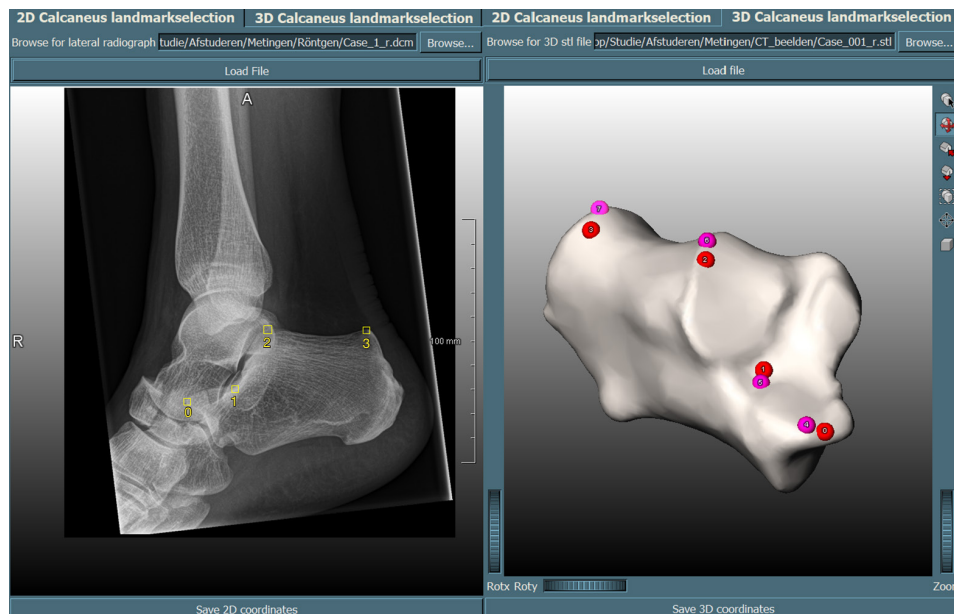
Screenshot of the developed Graphical User Interface to measure Böhler angle and the Critical angle of Gissane. (Left) two-dimensional radiographs measurements on the calcaneus; (right) 3D measurements on 3D models of the calcaneus. The selected landmarks by the observers are depicted with red, and the corrected landmarks by the algorithm with purple. [0] The most superior point of the anterior process; [1] the most inferior point of the posterior facet; [2] the most superior point of the posterior facet; and [3] the most superior point of the calcaneal tuberosity; [4] the most superior point of the anterior process corrected by the algorithm; [5] the most inferior point of the posterior facet by the algorithm; [6] the most superior point of the posterior facet by the algorithm; [7] the most superior point of the calcaneal tuberosity by the algorithm. 2D, two-dimensional; 3D, three-dimensional.
